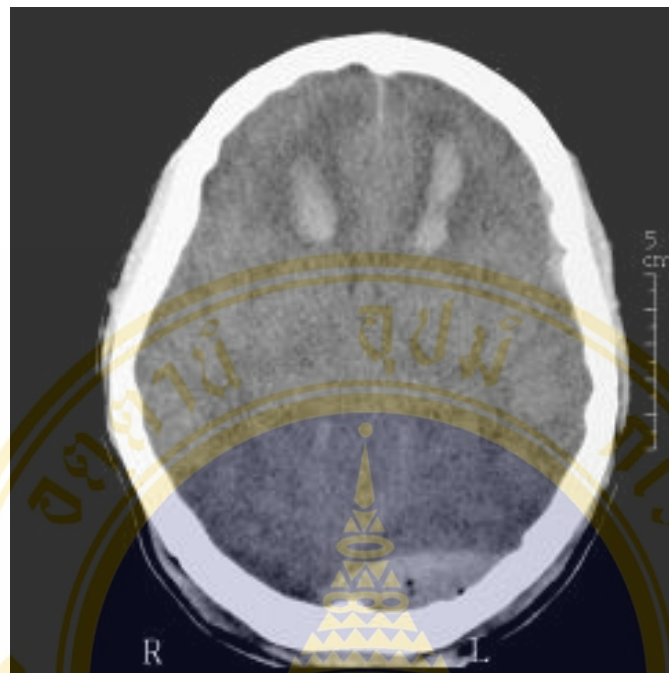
Cranial CT scan in soft tissue window (Fig.4-1A) and bony window (Fig.4-1B) shows air bubble entering into cranial vault resulting from fracture skull. The line of fracture skull in left occipital bone over epidural hematoma.
